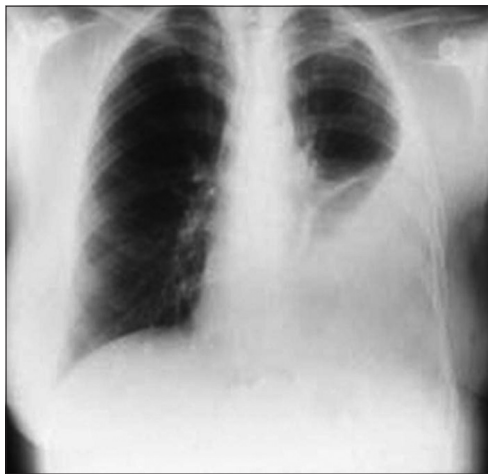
X-ray chest showing left-sided pleural effusion
